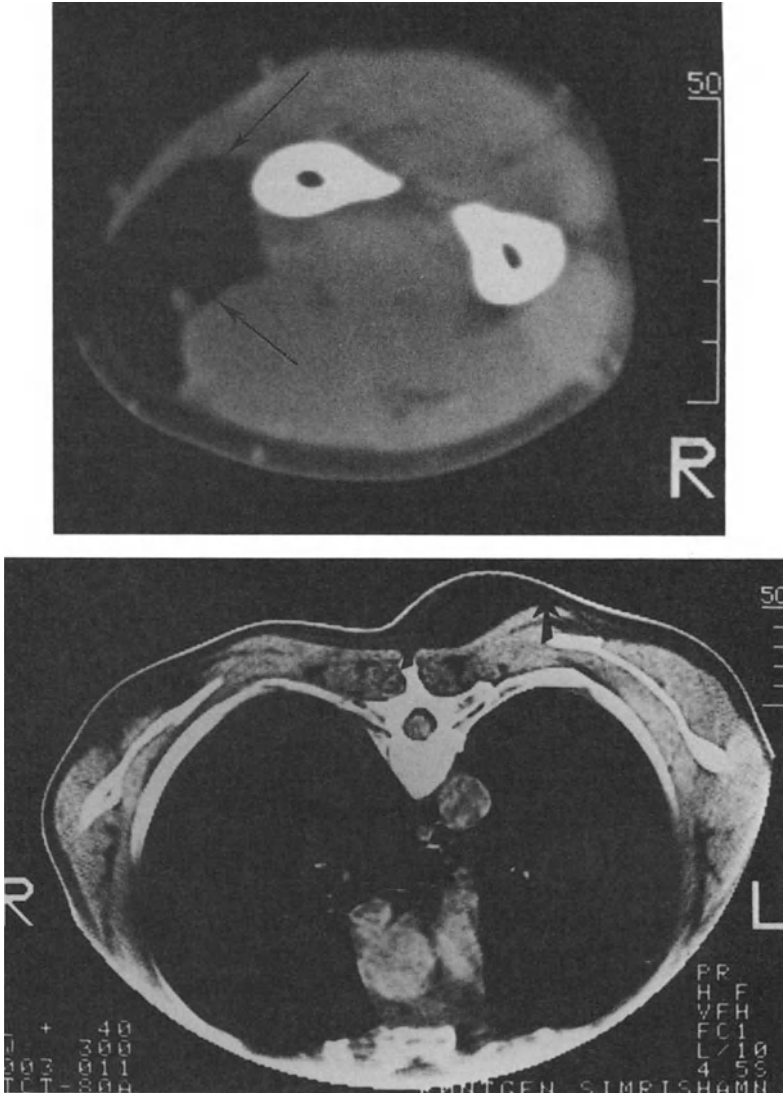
CT pattern; soft tissue lipoma. A: Subfascial lipoma, right forearm. The lesion is distinctly outlined by the adjacent flexor and extensor muscles of the forearm. It is transversed by a vessel but is otherwise of homogenous low density (arrows). B: Subcutaneous lipoma dorsally in the left chest wall. In this superficial location lipomas are less clearly seen, being isodense with the surrounding fat. A thin capsule surrounds the lipoma (arrows).
